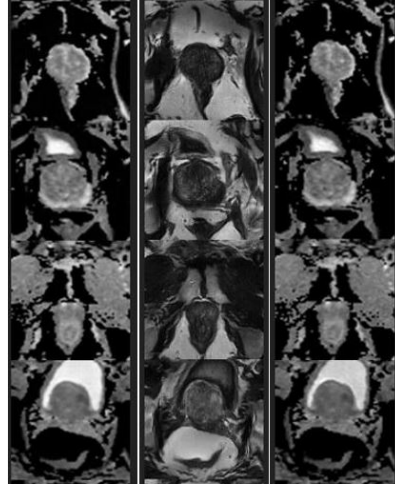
Preliminary DualGAN ADC to T2 to ADC Results: From left to right, one can visualize a patients’ scan in ADC Format transformed to T2-weighted and then back to ADC.
